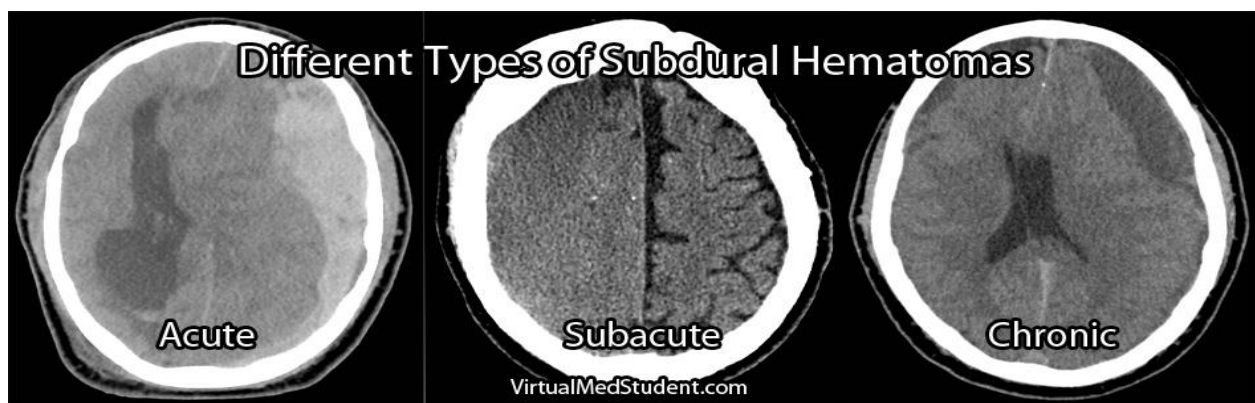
CT Brain Subdural Hematoma, (www.virtualmedstudent.com).
